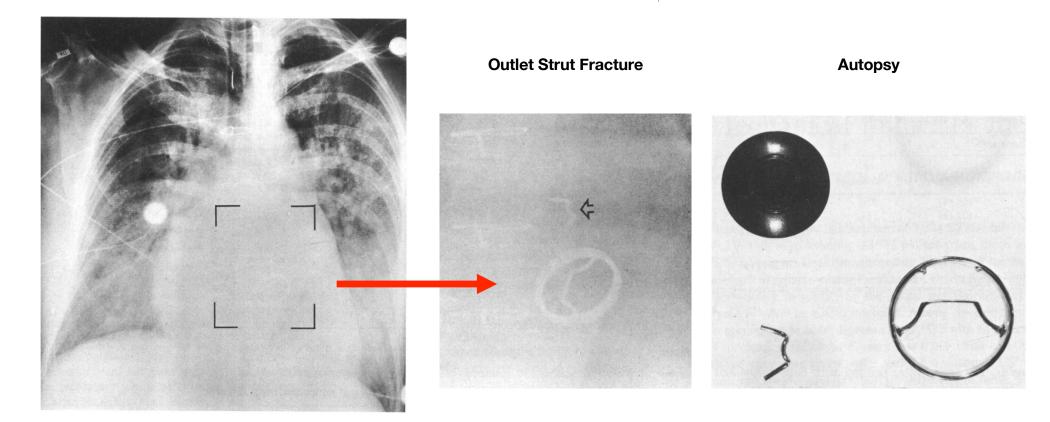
Chest x-ray film taken 24 hours before death (Patient 10, Table II). Severe pulmonary edema prevented the correct interpretation in time.
